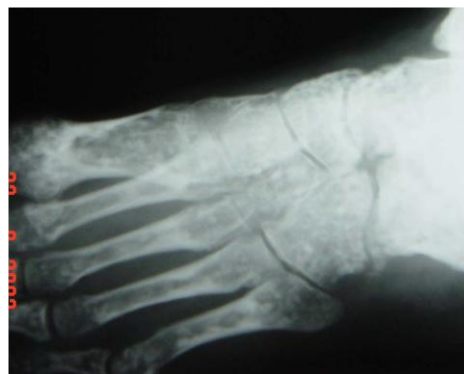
X-ray of metatarsal and tarsal ones of left foot showing small sclerotic areas in all five metatarsal bones and tarsal bones also. Note that sclerotic areas are more intense in spongiosa in epimetaphysis.
